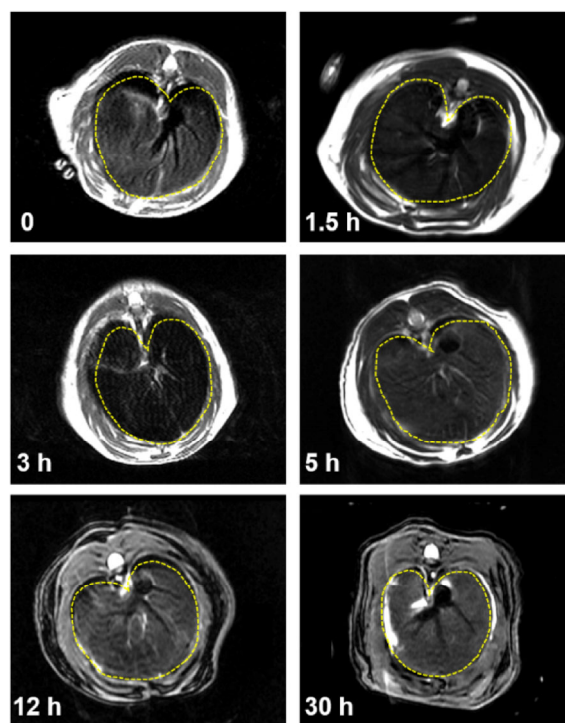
In vivo* T_2 -weighted MRI images of liver before and after intravenous administration of 0.84 mg Fe per kg body weight of $\text{Fe}_3\text{O}_4@\text{C}$ hybrids (after 0, 1.5, 3, 5, 12, and 30 h).
